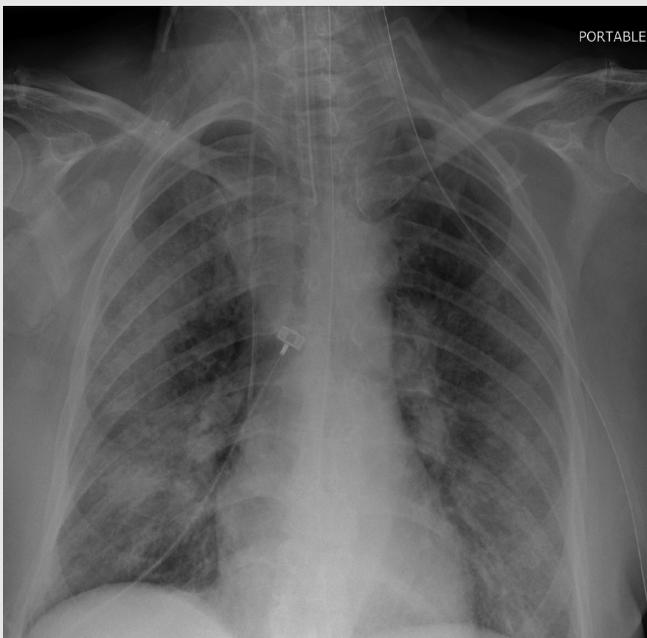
Chest x-ray nine days after presentation after intubation. This film reveals bilateral alveolar infiltrates.
